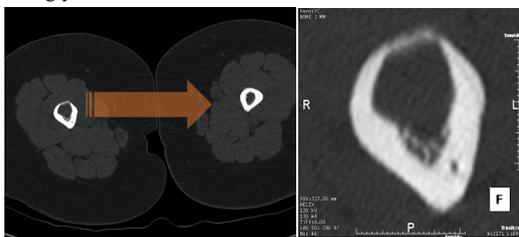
Axial CT and spot magnified image showing a mid-femoral diaphyseal expansile lytic lesion noted anteriorly. It measures 1.5 x 1.7 x 1.7 cm in AP, transverse and craniocaudal dimensions respectively. No internal matrix of calcification is demonstrated. The zone of transition with the adjacent cortex cannot be discerned. The anterior aspect of the cortex is markedly thinned with no evidence of cortical breakthrough. There's a solid adjacent periosteal reaction noted. No pathological fractures are demonstrated.
